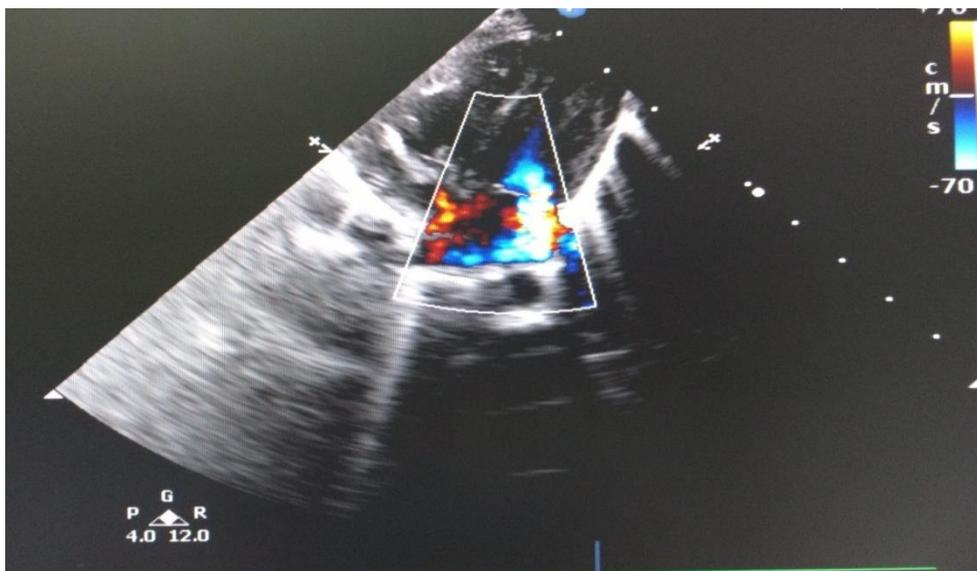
Color Doppler in the apical 4-chamber view shows moderate mitral regurgitation (first day of life).
